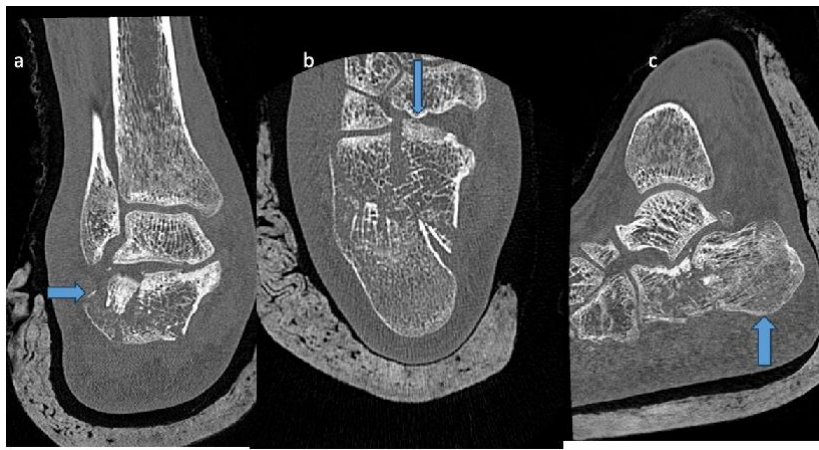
CT images (MPR) in coronal (a), axial (b), and sagittal planes (c) showing intra-articular fractures on the right
